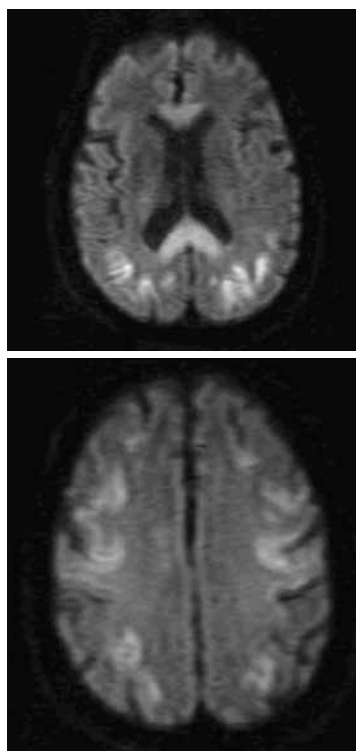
Axial DWI (isotropic b 1000) MR image showing an increased signal in the temporo-occipital grey matter and involving the genu and the anterior aspect of the corpus callosum
